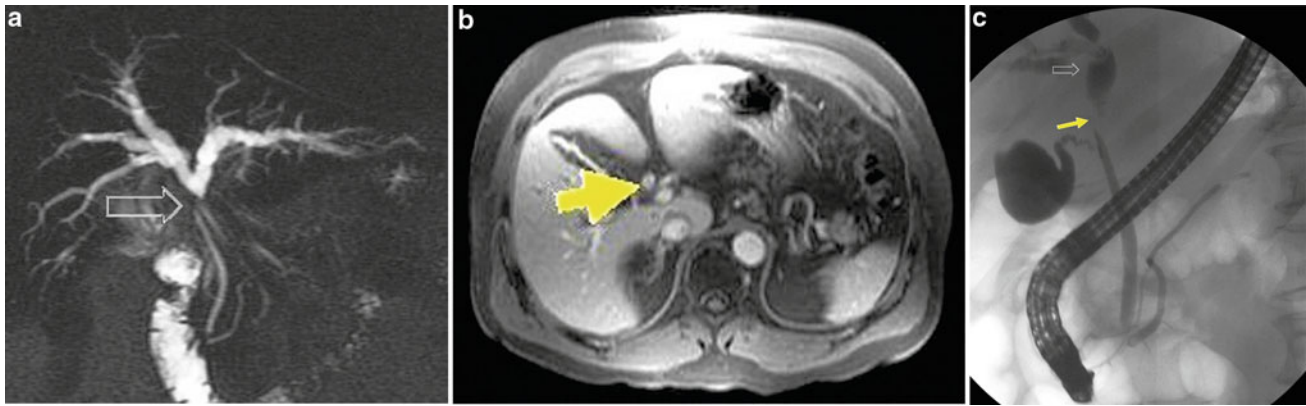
Klatskin tumor. a MRCP (2-cm-thick slab) shows intrahepatic bile duct dilatation and a short, tight stricture in the common hepatic duct next to the bifurcation (*arrow*). b Gadolinium-enhanced MRI (T1 fat-saturated gradient echo) reveals enhancement of the wall
